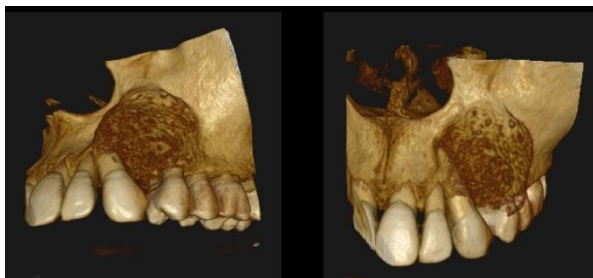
Radiograph shows the extent of the lesion.
